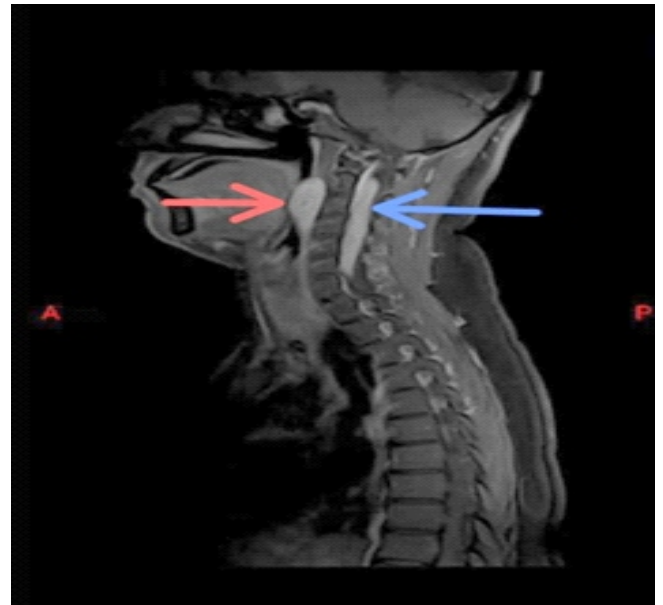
Sagittal view of the pre-op T1 weighted MRI; Blue arrow denotes the intra spinal schwannoma, Red arrow denotes the pre vertebral schwannoma.
